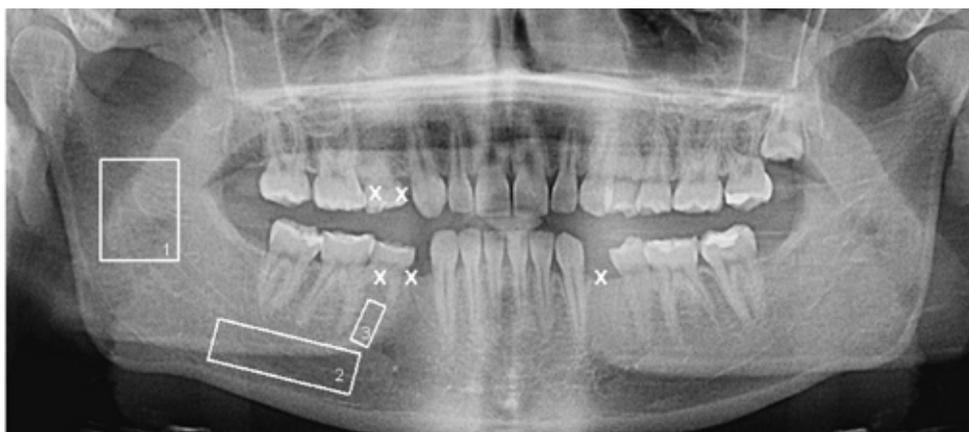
Panoramic radiograph of a hypodontia patient with Regions of Interest (ROI). Congenitally missing teeth are marked with an 'x'. The right upper and lower first and second bicuspid and the left lower first bicuspid are congenitally missing. ROI 1: Ascending ramus. ROI 2: Apically of the mandibular molars and parallel and above the cortical border of the mandible. ROI 3: Parallel to the mesial root of the first molar, stretching from the apex of the mesial root, to half way up the root.
